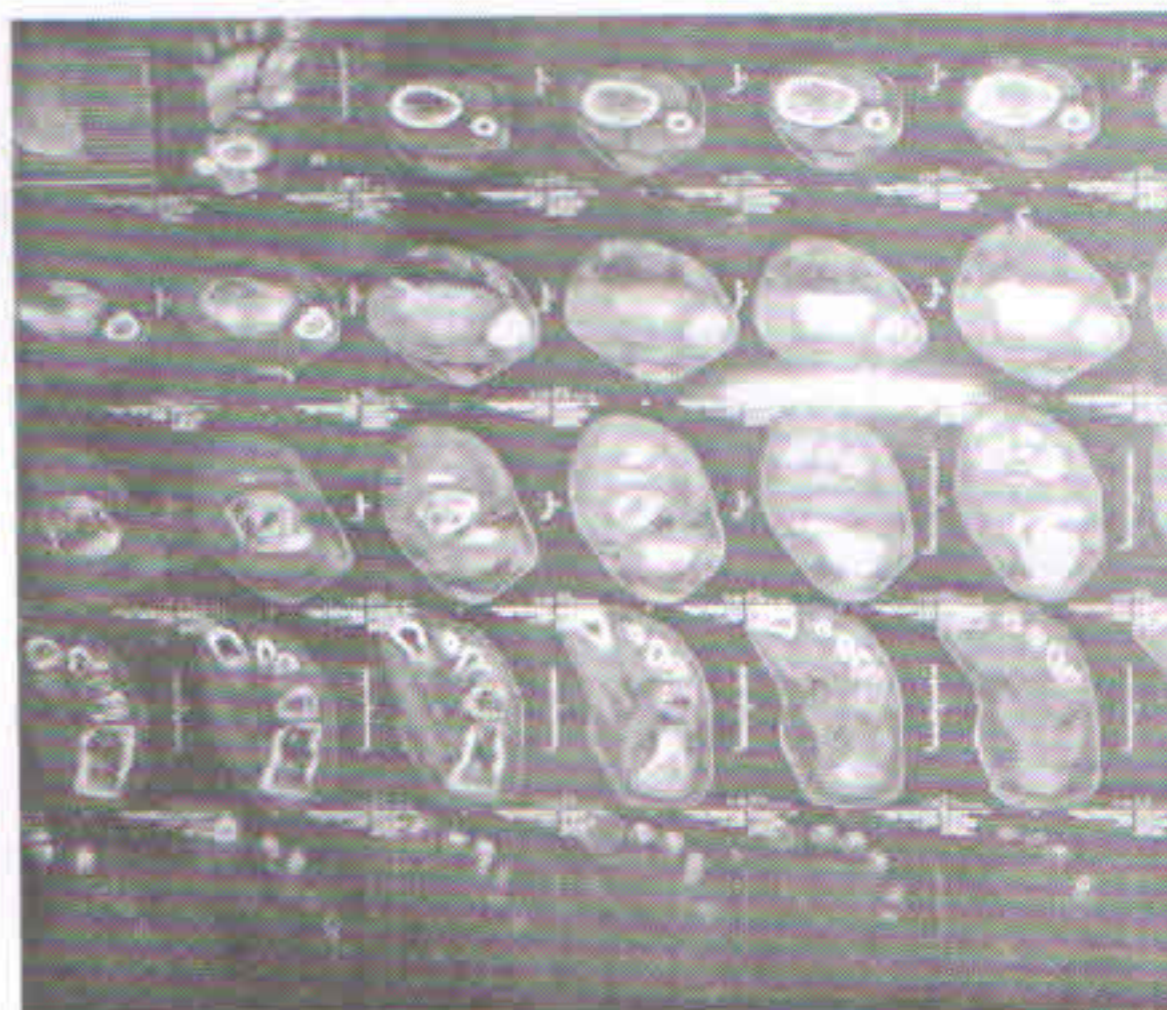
CT of right foot
